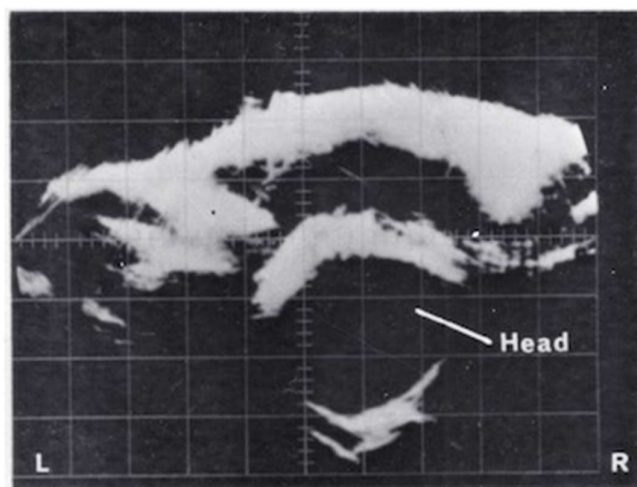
Bistable obstetric echogram (ultrasound image) of the fetal head from 1963. Image reproduced with permission from the Australasian Society of Ultrasound in Medicine.
